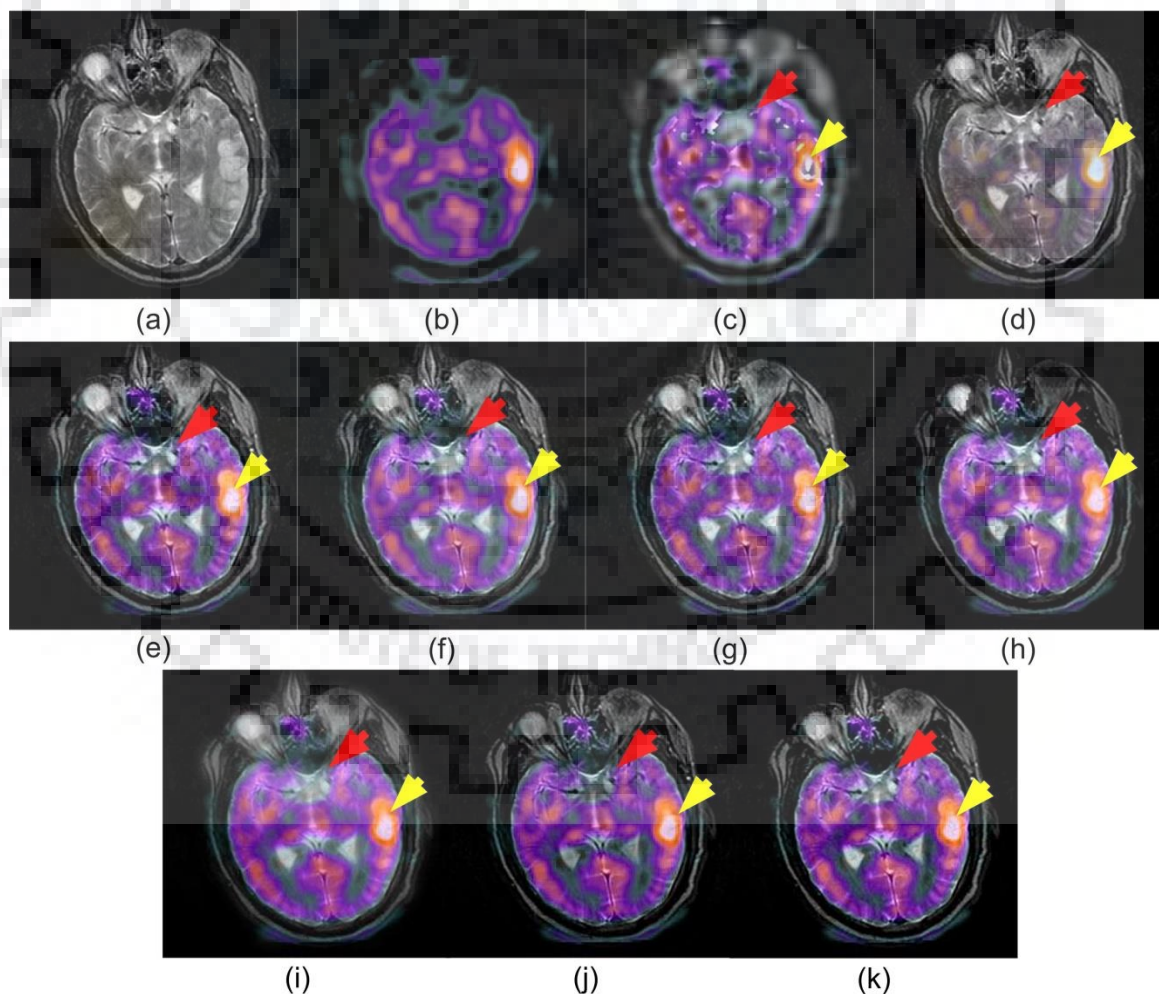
Input image pair-3 (a) MR image (b) SPECT image, qualitative comparisons of fused images obtained by (c) Bhatnagar et al., 2013 [18] (d) Li et al. 2013 [94] (e) Yang et al., 2015 [200] (f) Yang et al. 2016 [201] (g) Yang et al., 2017 [203] (h) Liu et al., 2017 [111] (i) Hermessi et al., 2018 [57] (j) Hou et al., 2019 [59] (k) Proposed CNN-MIF
